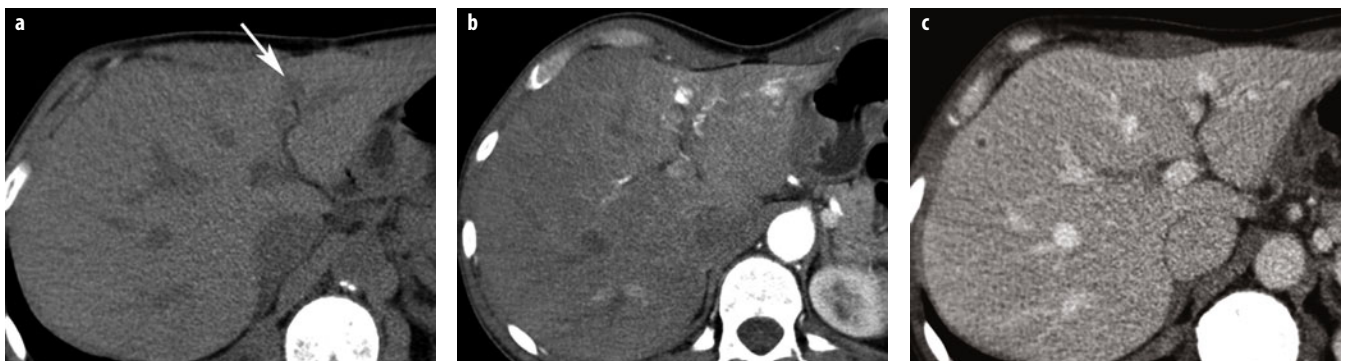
a-c. Hemangioma type 1. a Unenhanced computed tomography (CT) shows a small, hypodense lesion adjacent to the falciform ligament (*arrow*). b Contrast-enhanced CT in the arterial phase shows rapid and complete enhancement of the hemangioma, which persists in the venous phase (c). Attenuation of the hemangioma in the enhanced phases is similar to that of the aorta
